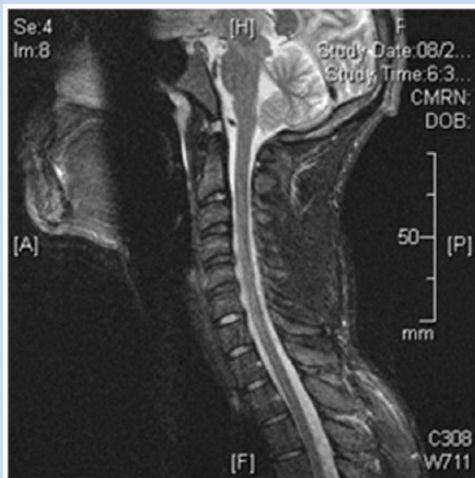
Immediate postinjury magnetic resonance image demonstrating intact spinal cord canal with cerebrospinal fluid signal surrounding the spinal cord at all levels.
